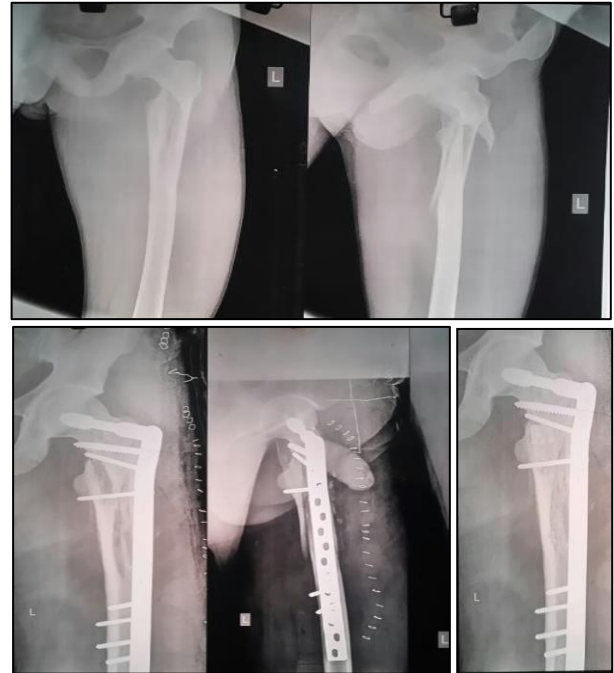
Pre-op and post-op X-rays treated with DCS (case 1).
